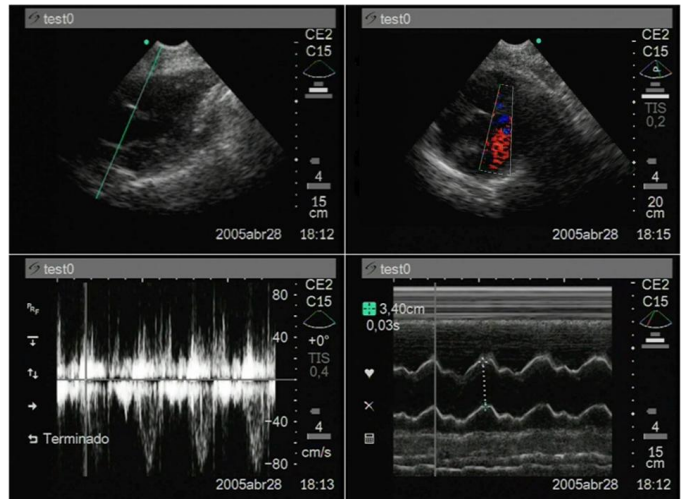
B Mode (top left), Color Doppler Mode (top right), Pulsed and Continuous Doppler Mode (bottom left) and M Mode (bottom right).
